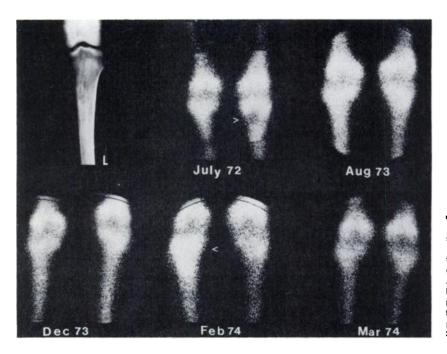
Proximal tibia and tibial epiphysis infarctions. Tomogram of proximal left tibia during episode of acute pain showing spotty demineralization. July 1972: Cold area (arrow) in proximal left tibia corresponding to region of radiographic change and clinical symptoms. August 1973: Scintigram returns to normal. December 1973: Normal scintigram during period of acute pain in proximal right tibia. February 1974: Increased uptake in proximal right tibia (arrow). March 1974: Scintigram returns to normal.
